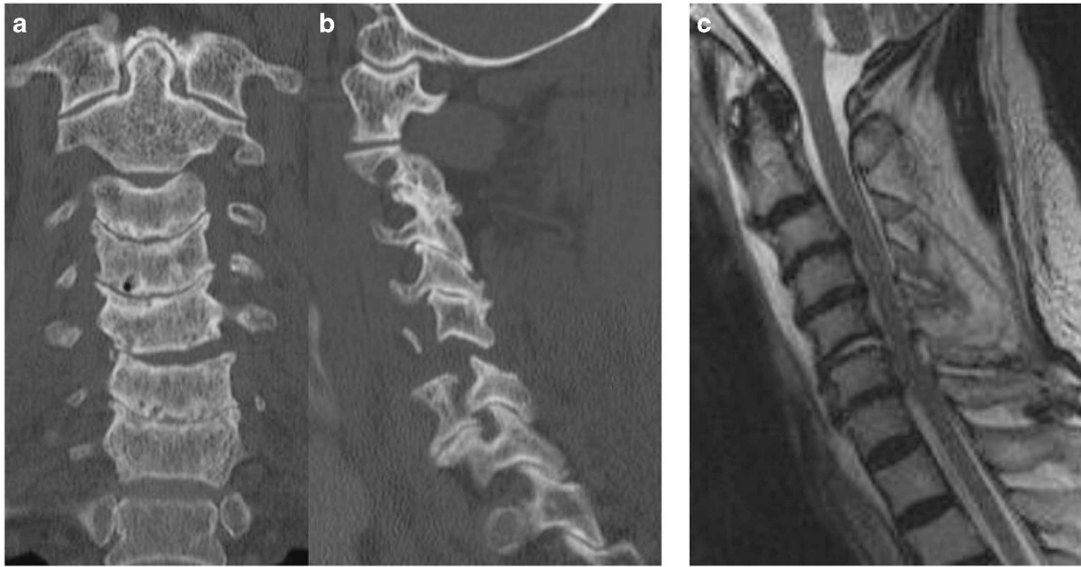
Preoperative CT scans of the cervical spine (a, b). The C5/6 joint was dislocated without any fractures. Preoperative MR image of the cervical spine (c). The intervertebral disk of C5/6 and the posterior ligamentous complex were ruptured and hemorrhage was spreading into the paravertebral muscles, retropharyngeal space and epidural space.
